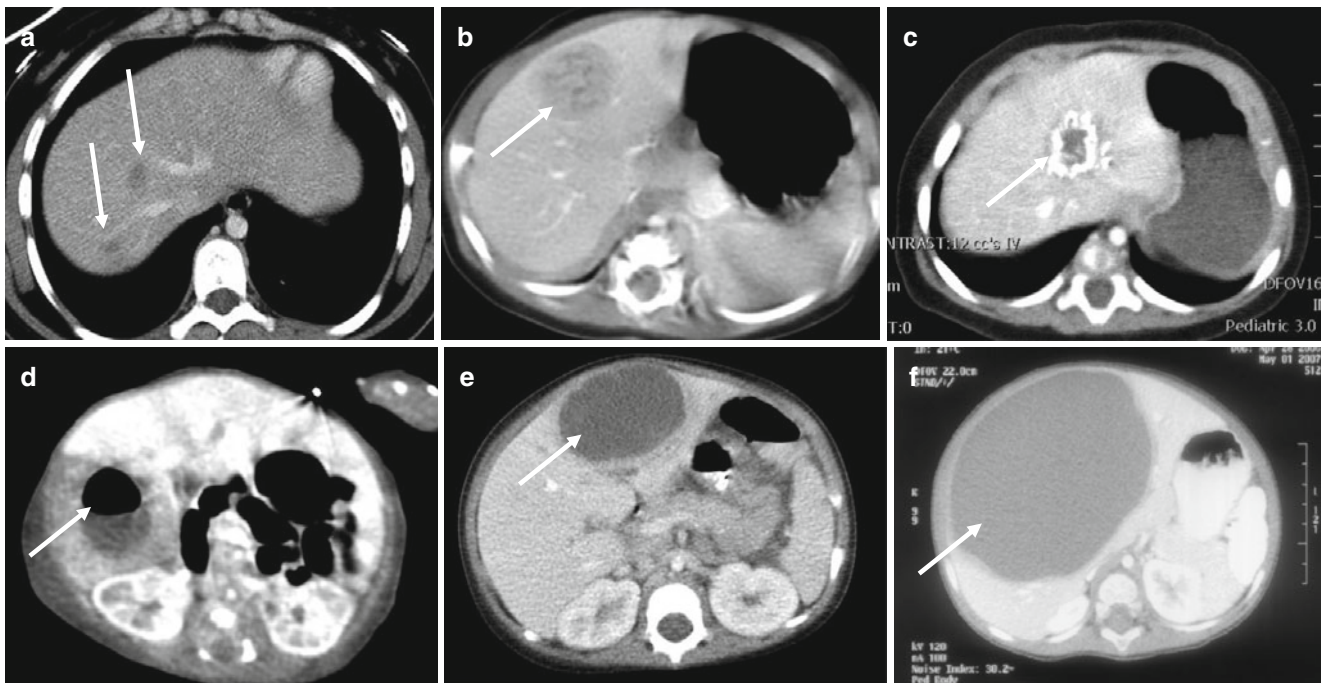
Differential diagnosis: Radiographic appearance of non-neoplastic masses and cysts. (a) Multiple small bacterial abscess in a child with chronic granulomatous disease; (b) Inspissated bile lake in a child with biliary atresia and cholangitis; (c) organizing hematoma in a newborn with sepsis and coagulopathy; (d) infarction of right lobe
